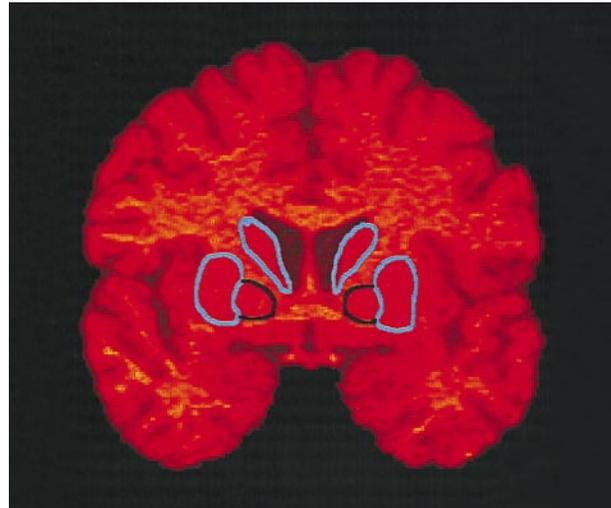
Examples of manual tracings of the striatum (blue line; the caudate is located superiorly, the putamen inferiorly) and the globus pallidus (black line) from a reformatted coronal magnetic resonance image.
